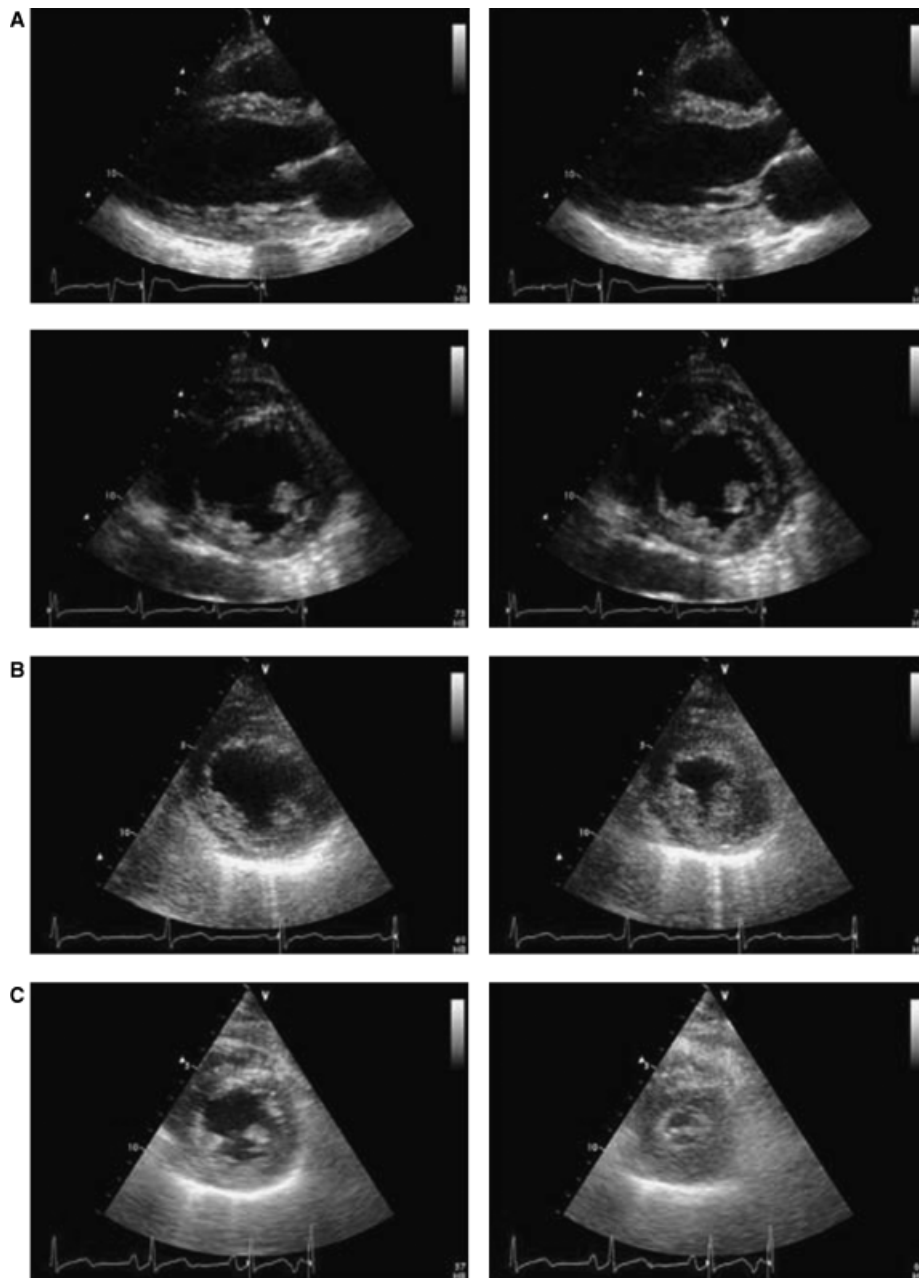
Representative end-diastolic (left column) and end-systolic (right column) frames of echocardiograms on presentation (A), 10 months later (B), and 2.5 years after the initial presentation (C). (A) Both the parasternal long axis views (top) and short axis views (bottom) are shown. B and C demonstrate the parasternal short axis views. Note the gradual decrease in left ventricular chamber size, as well as an increase in fractional shortening and systolic wall thickening over time.
